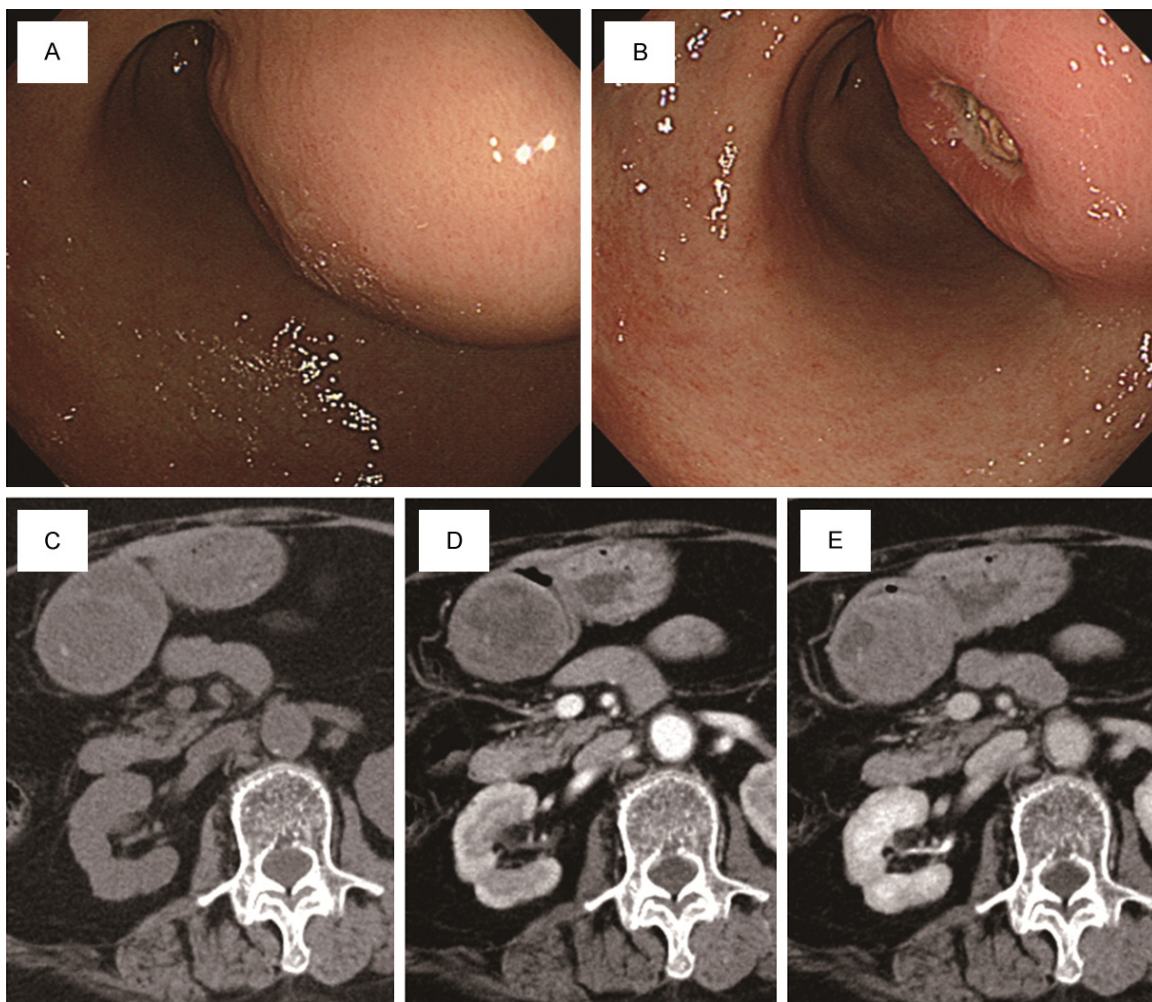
Findings of upper gastrointestinal endoscopy and computed tomography (CT). A, B. Upper gastrointestinal endoscopy revealed a gastric mass resembling a submucosal tumor with an ulcerated depression on its surface. C. On CT, most of the mass showed low density. D. During the arterial phase of contrast-enhanced CT, the mass displayed slight enhancement. E. During the late phase of contrast-enhanced CT, the mass displayed mild enhancement.
